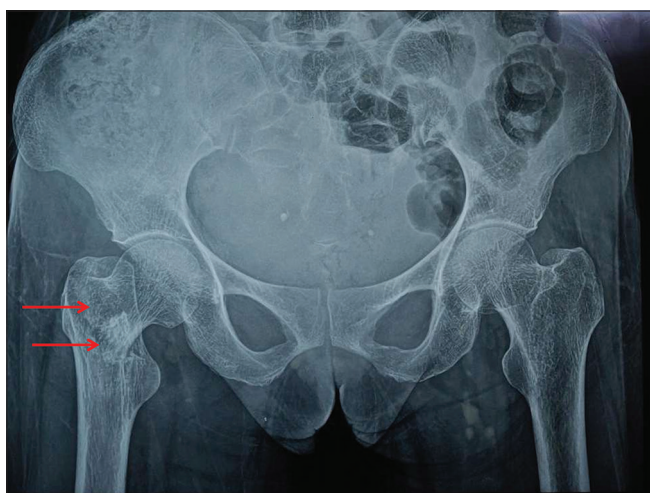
Anteroposterior radiograph of pelvis. The red arrows show fractured neck of right femur
